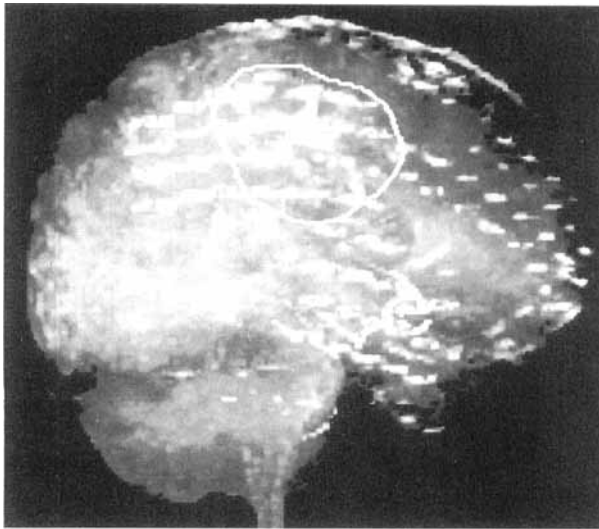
Magnetic resonance imaging three-dimensional rendered image (Patient 1), using a maximum intensity projection showing location of subdural grid electrode placement and delineation of region of increased α - $[^{11}\text{C}]$ methyl-L-tryptophan ($[^{11}\text{C}]$ AMT) uptake. The position of the grid electrode array on top of the exposed cortical surface can be recognized due to the small distortions of the magnetic field in the vicinity of the metal electrodes. The circular line delineates the region of increased $[^{11}\text{C}]$ AMT uptake in the frontoparietal region.
